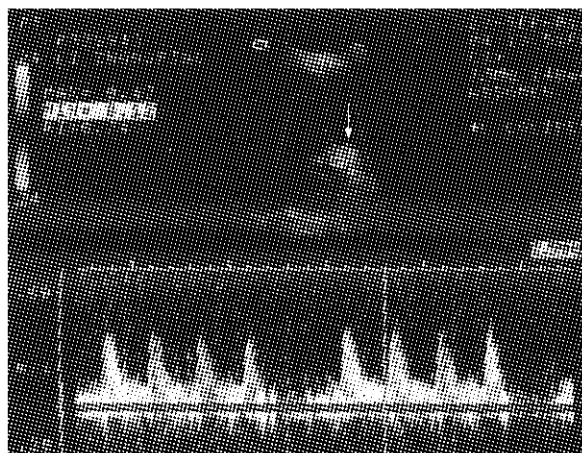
Ultrasonography after thrombectomy and arterial reconstruction. The blood flow of the hepatic artery was detected by ultrasonography again after thrombectomy and arterial reconstruction, the maximum hepatic artery blood flow was 0.47 m/s.
